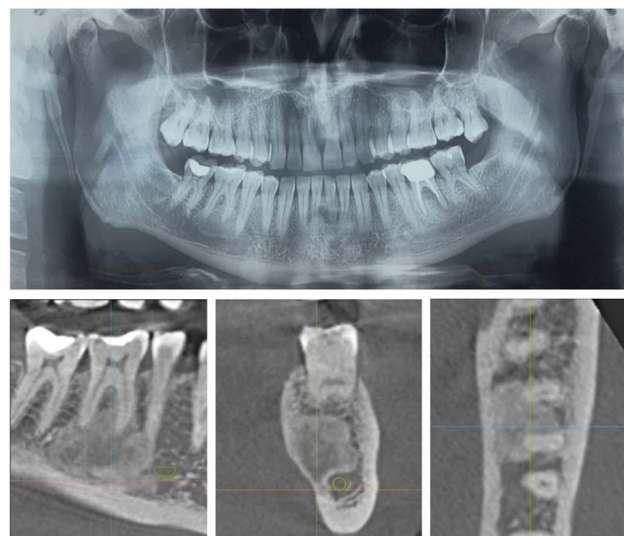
Radiographic images: orthopantomography, and coronal, axial, and panoramic CBCT sections of the osteosclerotic lesion.
